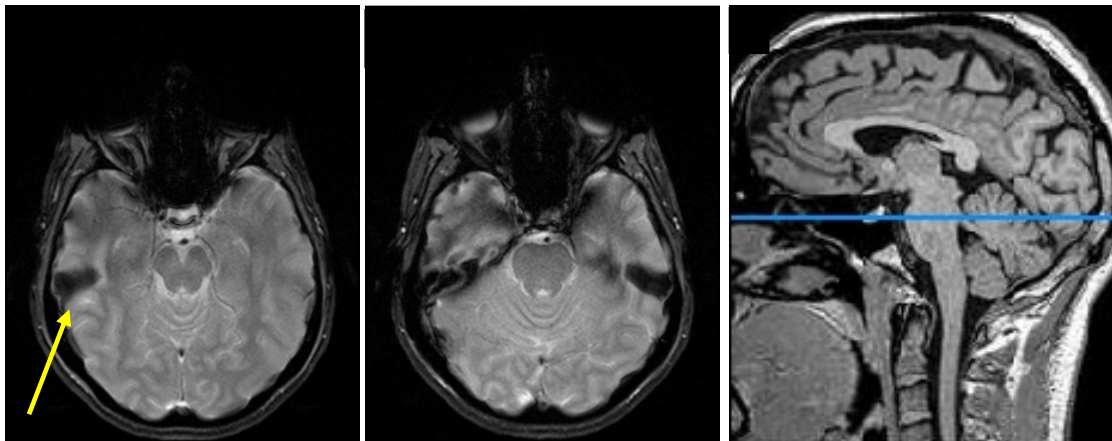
Dark lesion appearing in the right hemisphere (left, arrow). The next image in the series (middle) shows that both sides are symmetric. An example of the sagittal anatomy on T1-weighted imaging (<https://www.imaaios.com/en/e-Anatomy/Head-and-Neck/Brain-MRI-3D>) with the level of the "lesions" shown
